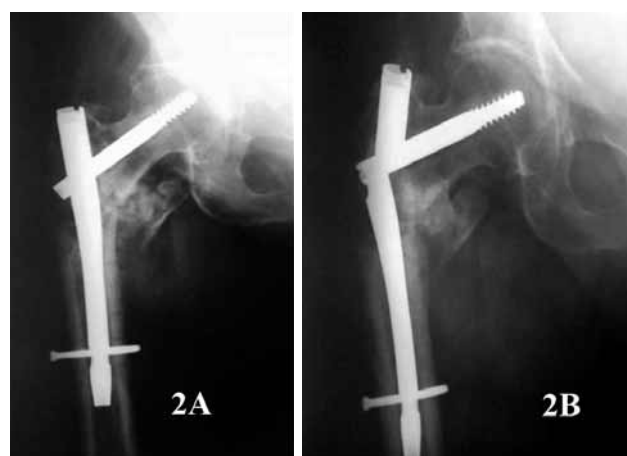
A – AP radiograph showing insufficient reduction with lateral cortical wall deficiency and the unsolved posteromedial cortical buttress. The main fragments are distracted. B – signs of non-union and nail breakage at the aperture for the lag screw, 11 months after surgery.
